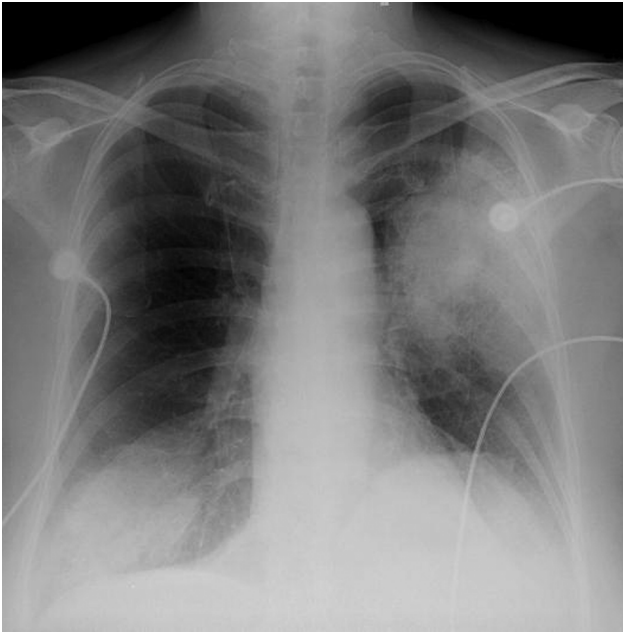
Portable chest radiograph taken on presentation to the emergency department, prior to intubation. There are consolidations and air bronchograms in the right-lower and left-upper lobes, which suggests multilobar pneumonia.
